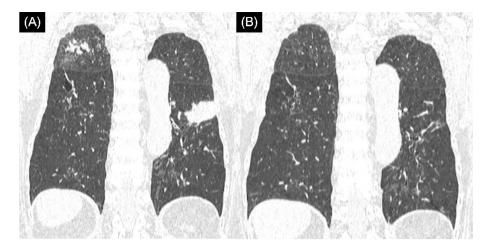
Computed tomography (CT) of the chest. (A) Wedge-shaped infiltration shadows and clusters of nodules are apparent during exacerbation of allergic bronchopulmonary aspergillosis. (B) The infiltrating shadows and clusters of nodules are much less prominent after 6 weeks of treatment with dupilumab.
